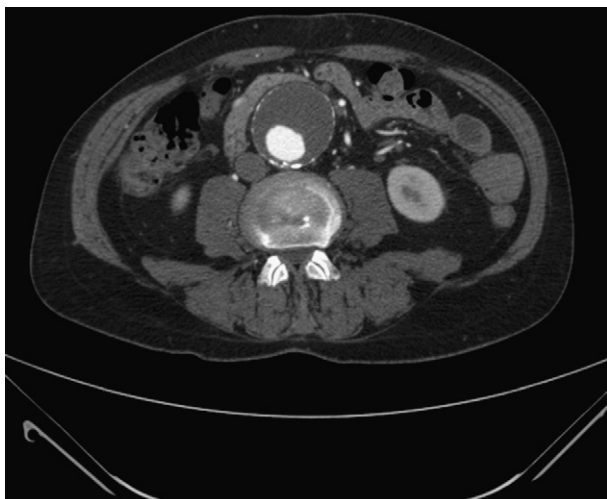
CT angiogram demonstrating 5.3 cm AAA without evidence of rupture or leak.
